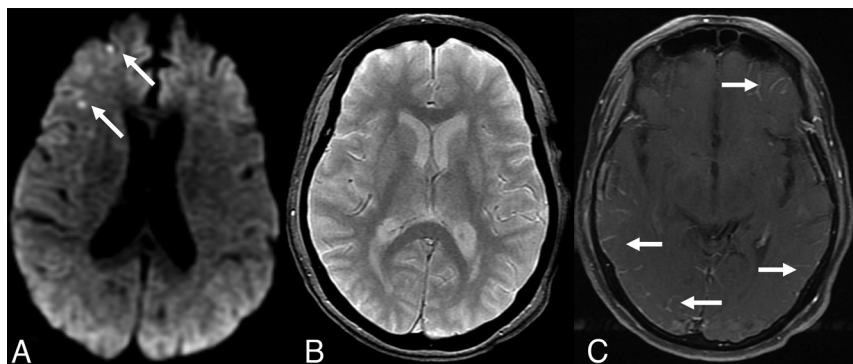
MR imaging at 1.5T obtained in the emergency department. Axial DWI (A), T2*-GRE (B), and contrast-enhanced T1-TSE (C) images at identical section levels. A, Arrows show punctuate areas of restricted diffusion in the right frontal cortex. There were a few more similar foci in other regions of the brain (not shown). B, T2*-GRE was negative for any intracranial hemorrhage or cerebral microbleeds. C, Arrows point to bilateral multifocal abnormal leptomeningeal enhancement.
